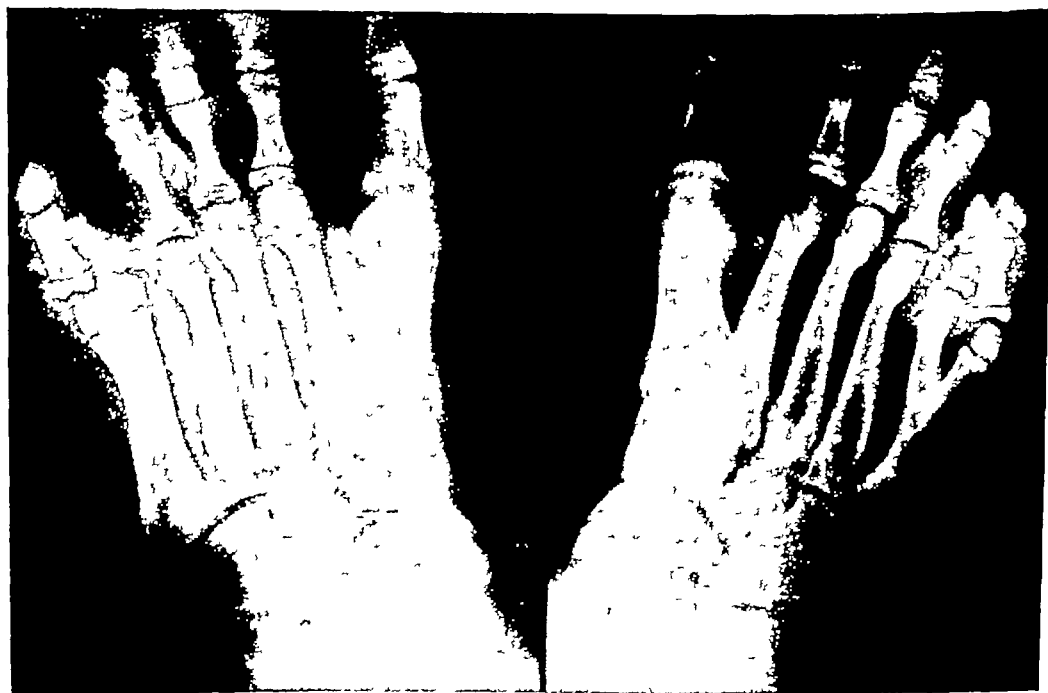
Roentgenogram of foot of brother of patient represented in Fig 382, A Note fifth digits amputated in infancy without reshaping of metatarsals Remaining epiphysis of base of proximal phalanges and accessory metatarsals became constantly pressured points
